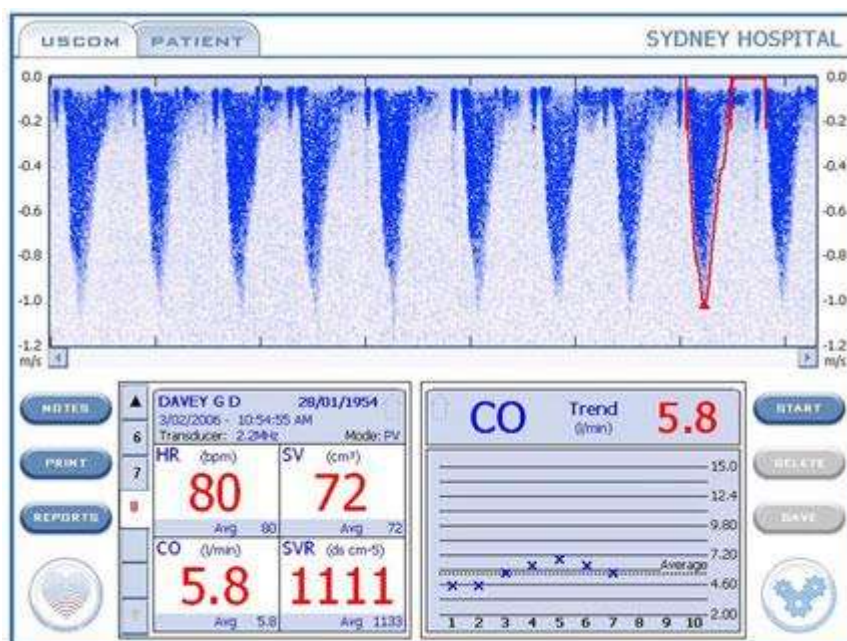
Beat to beat quantitative evaluation of haemodynamic parameters. The screen shows Doppler tracing of pulmonary valve Doppler flow. Below numerical readings of haemodynamic parameters are displayed. On the lower right side of the screen, measured cardiac output value and its trending pattern are shown. Adopted from: <https://www.intechopen.com/books/artery-bypass/minimally-invasive-cardiac-output-monitoring-.2012>.
